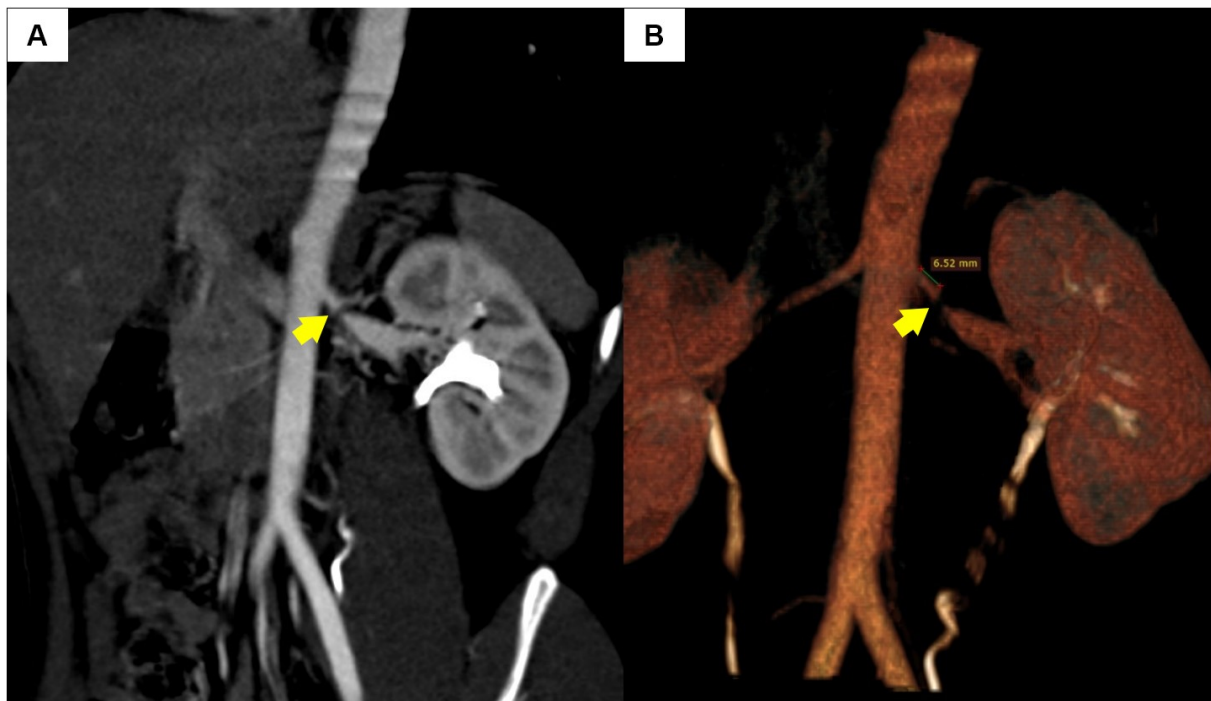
Coronal Oblique reformatted CT angiography (A) and 3D rendering image (B) shows a short segment stenosis of the left main renal artery (yellow arrow). The post-stenotic segment is dilated with multiple collateral vessels. The stenotic segment is about 6.5mm from the renal artery ostium.
